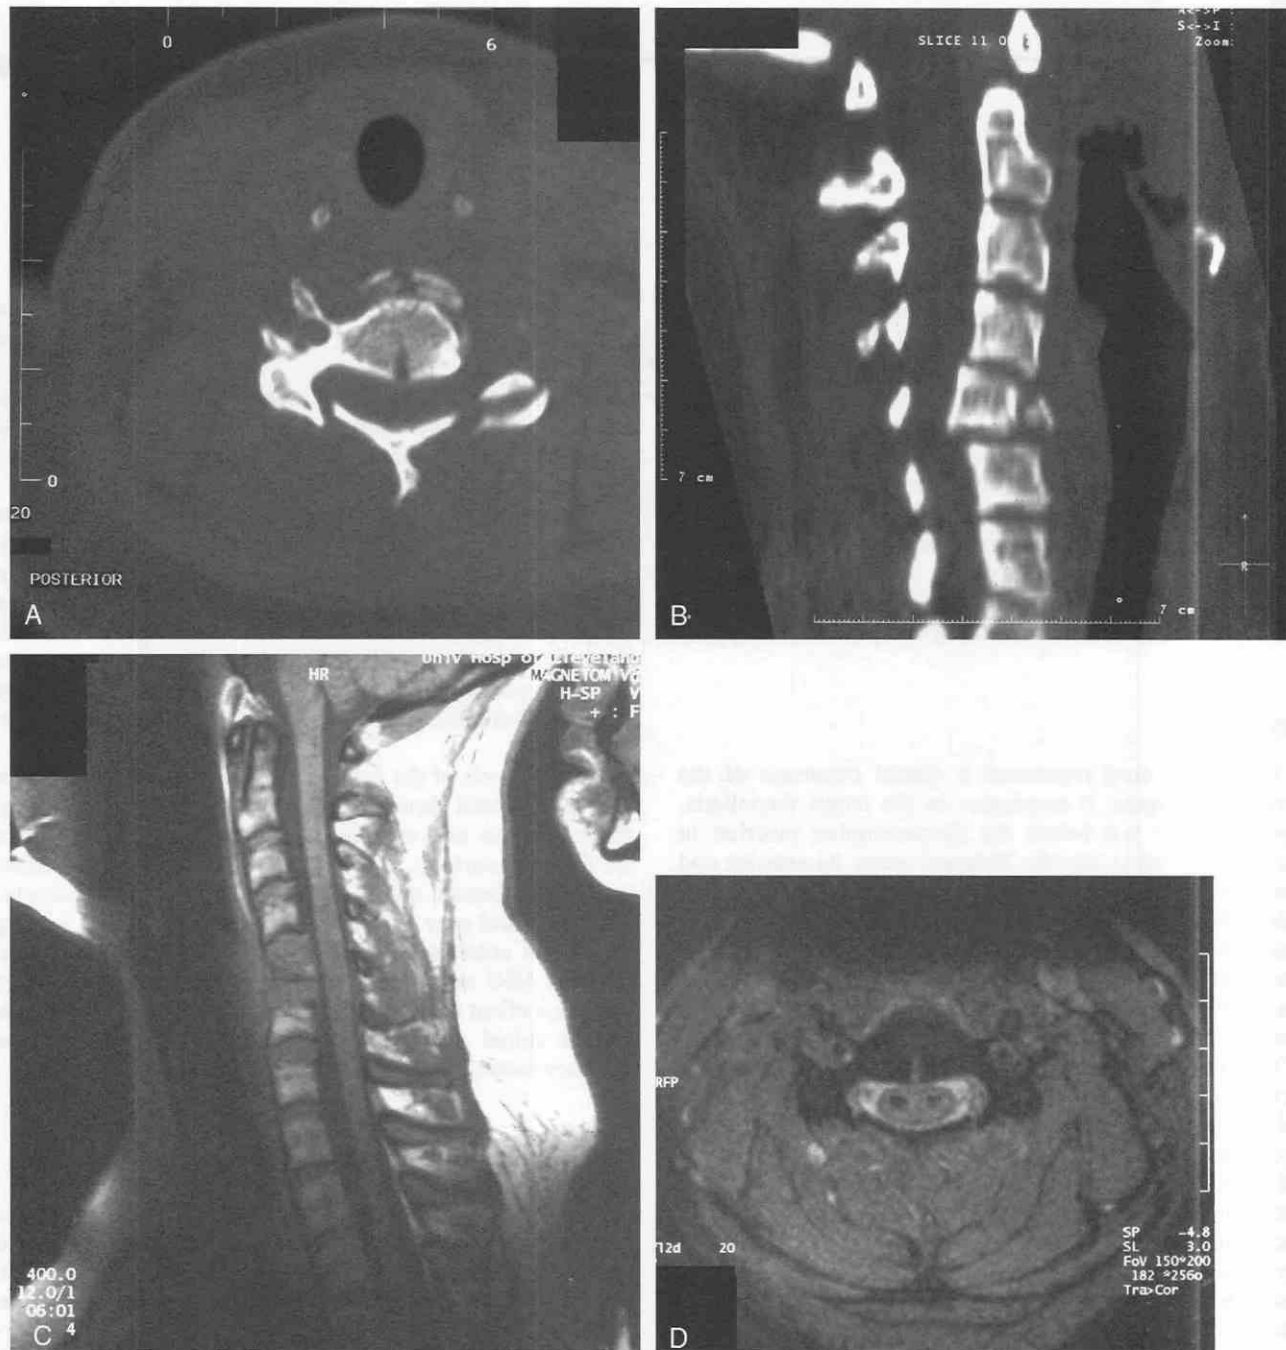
Spinal cord trauma with intramedullary hemorrhage. *A*, Axial CT section reveals the comminuted fracture of the vertebra and posterior elements with compression of the spinal canal. *B*, Sagittal CT reconstruction shows the anterior fracture of C5 and the posterior displacement of bone into the spinal canal. *C*, T1-weighted sagittal MR demonstrates the abnormal hypointense marrow signal in C5 from edema as well as the mild loss of height and again the posterior extension. No definite cord abnormality is seen. *D*, This axial FLASH (fast low-angle shot) T2-weighted section reveals two foci of abnormal hypointense regions within the cord from acute blood products.
